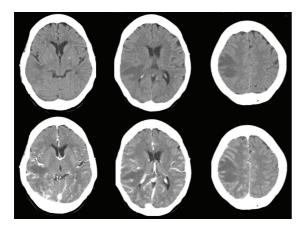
CT brain with contrast media of the first patient showing a hypodense lesion without abnormal enhancement in the right frontotemporoparietal lobe with surrounding vasogenic edema and a 0.4 cm midline shift.
